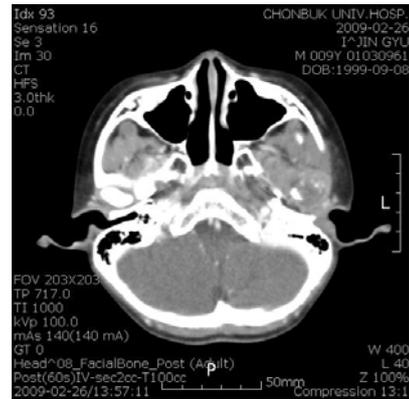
Horizontal view of CT
